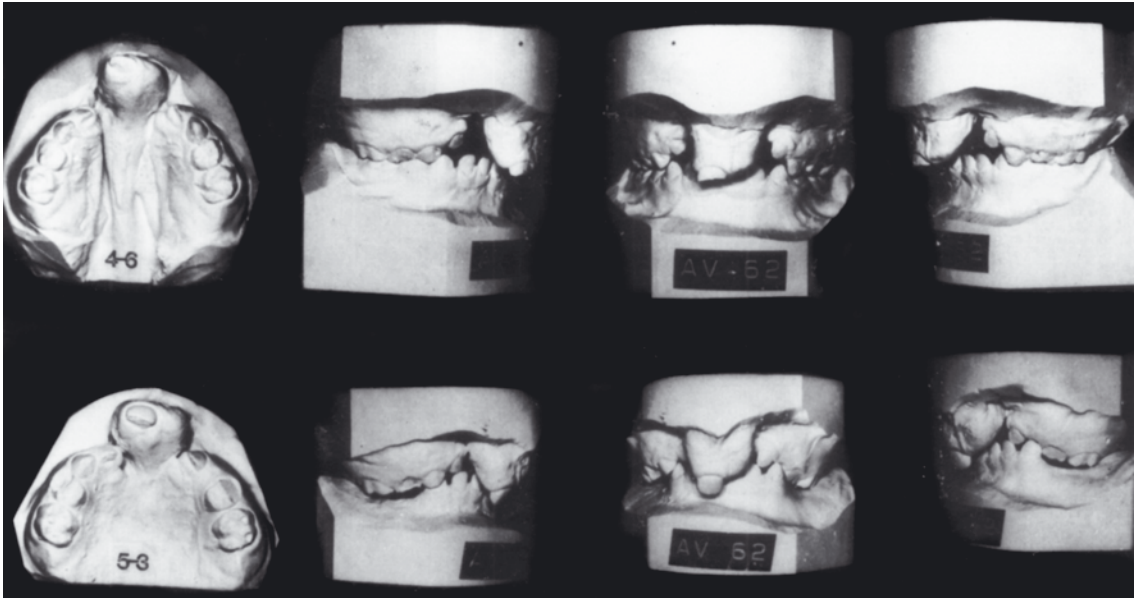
50. Case CT (AV-62) demonstrates a severe premaxillary overjet leading to a retruded midface and the successful use of protraction orthopedics. This patient was adopted from Central American parents. 4-6 It is important to note the wide cleft
